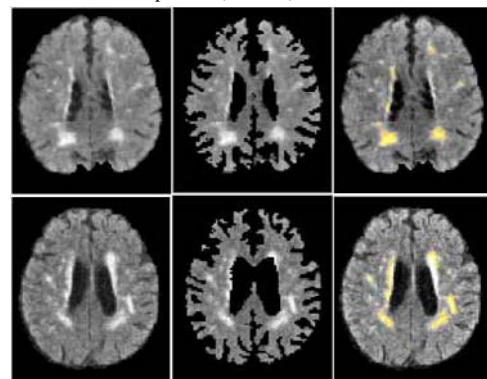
Two LLD patients FLAIR image (Left), Segmented WM image (Center), Detected WMHs (Right)
